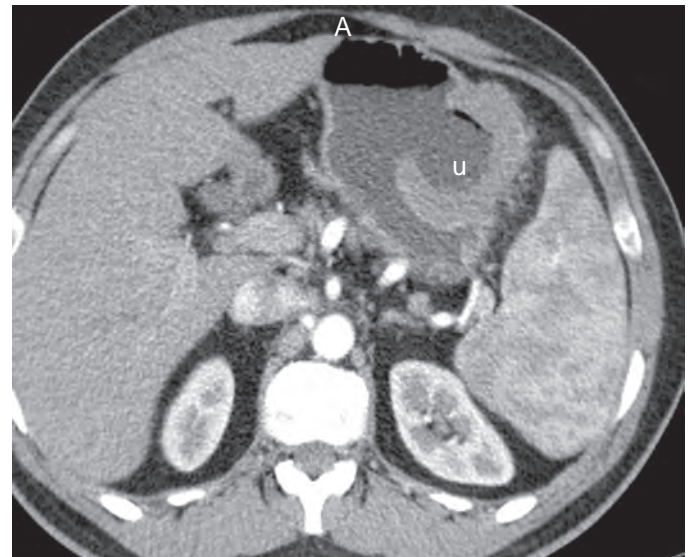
Ulcerated gastric lymphoma on CT. A large ulcer crater (u) is present within a soft tissue mass in the stomach. A, gastric antrum.
